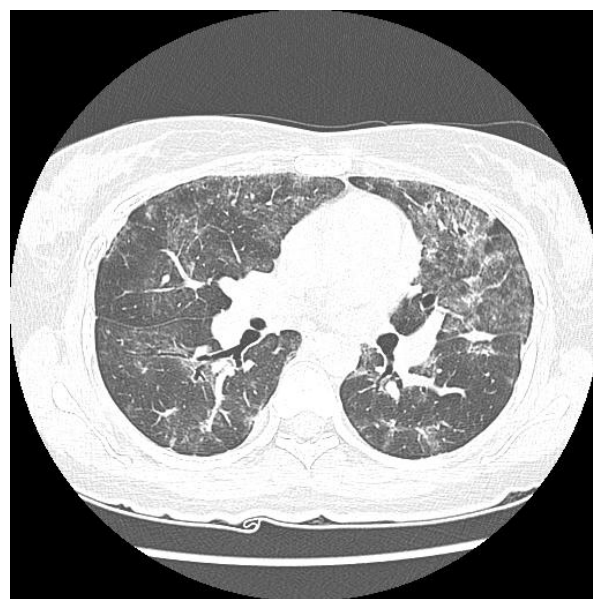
HRCT scan of idiopathic BOOP demonstrates the peribronchial distribution of multifocal, ill-defined ground glass opacities.
